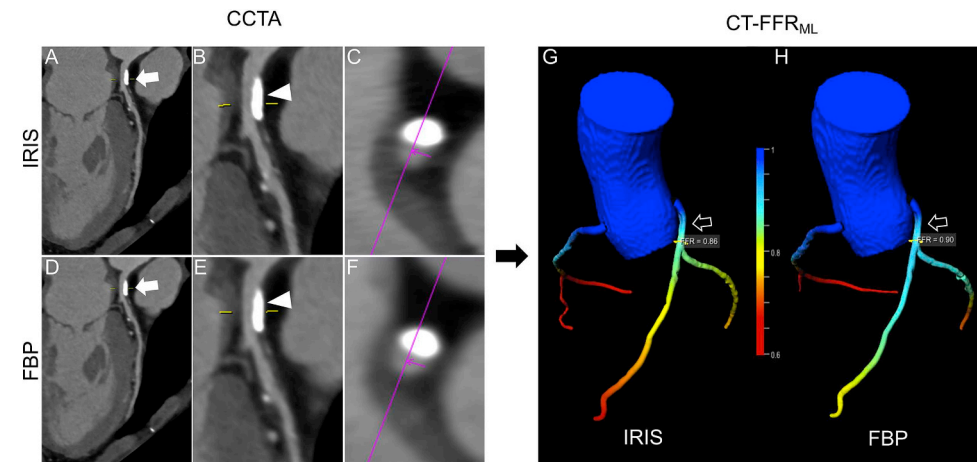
Curved MPR (A) and transverse section (C) of IRIS and corresponding FBP datasets (D and F) showing a calcified plaque (A and D, white arrows) causing moderate stenosis of the LM artery in a 49-year old woman. B and E show a close-up of the calcified plaque (white arrowhead). IRIS (G) and FBP-based (H) color-coded 3D mesh reveals different values (CT-FFR_{ML}: 0.86 vs 0.90). (For interpretation of the references to color in this figure legend, the reader is referred to the Web version of this article.)
